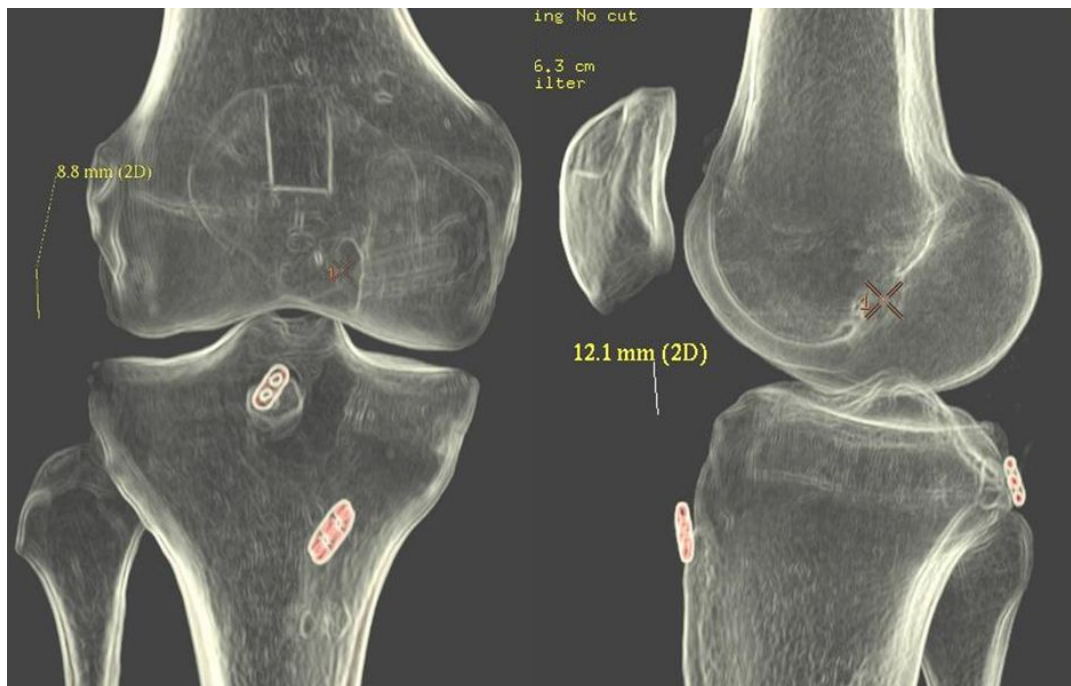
Postoperative x-rays
